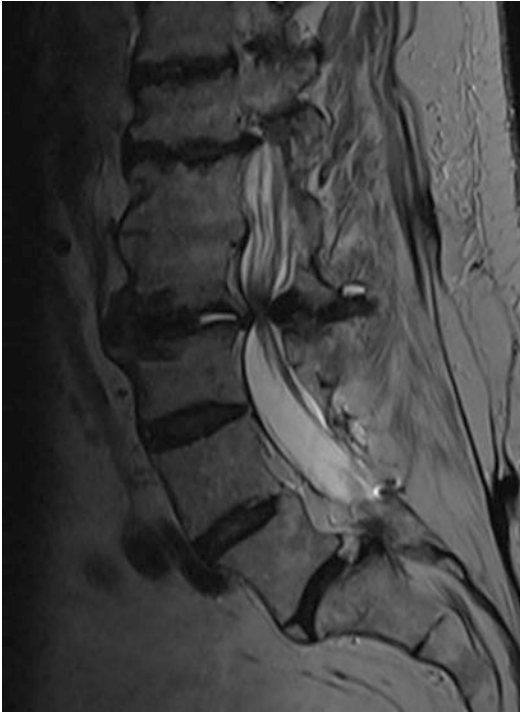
A midsagittal MRI image demonstrating severe narrowing at L2–L3
